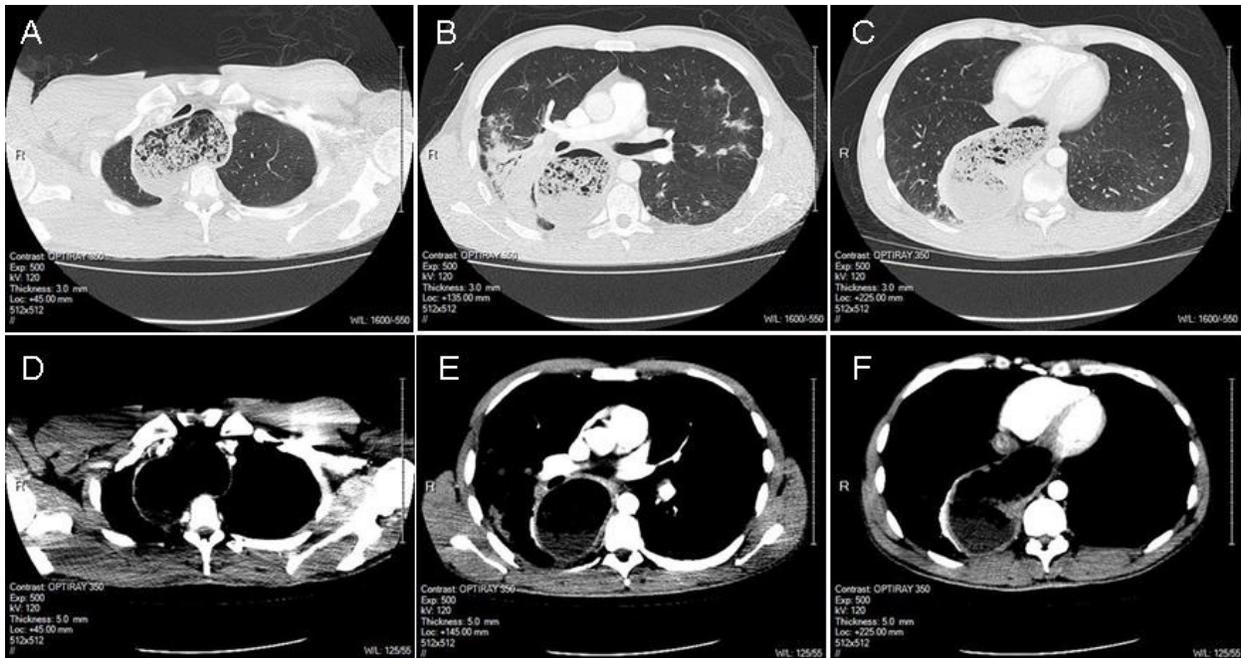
Selected static images from thoracic CT scan. Panels A-C: lung windows. Panels D-F: soft tissue windows.
